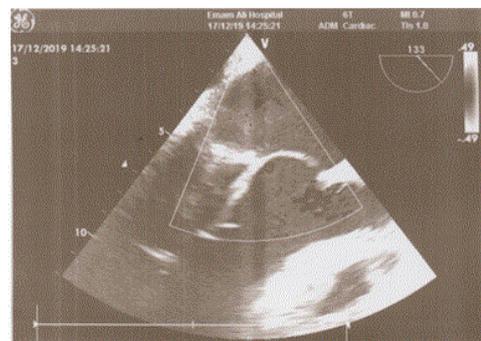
Follow up echocardiography of the newly created pericardial mitral valve
